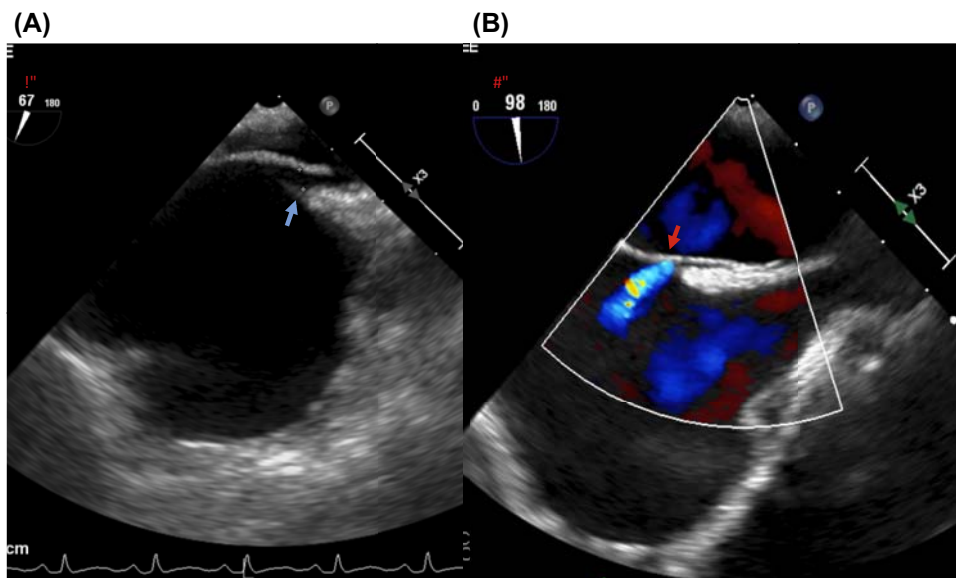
Bicaval view by transesophageal echocardiography showing the presence of PFO (*blue arrow*) that is partially open (A) resulting in baseline left-to-right shunting, indicated by the Doppler color flow across the PFO (*red arrow*) (B).
